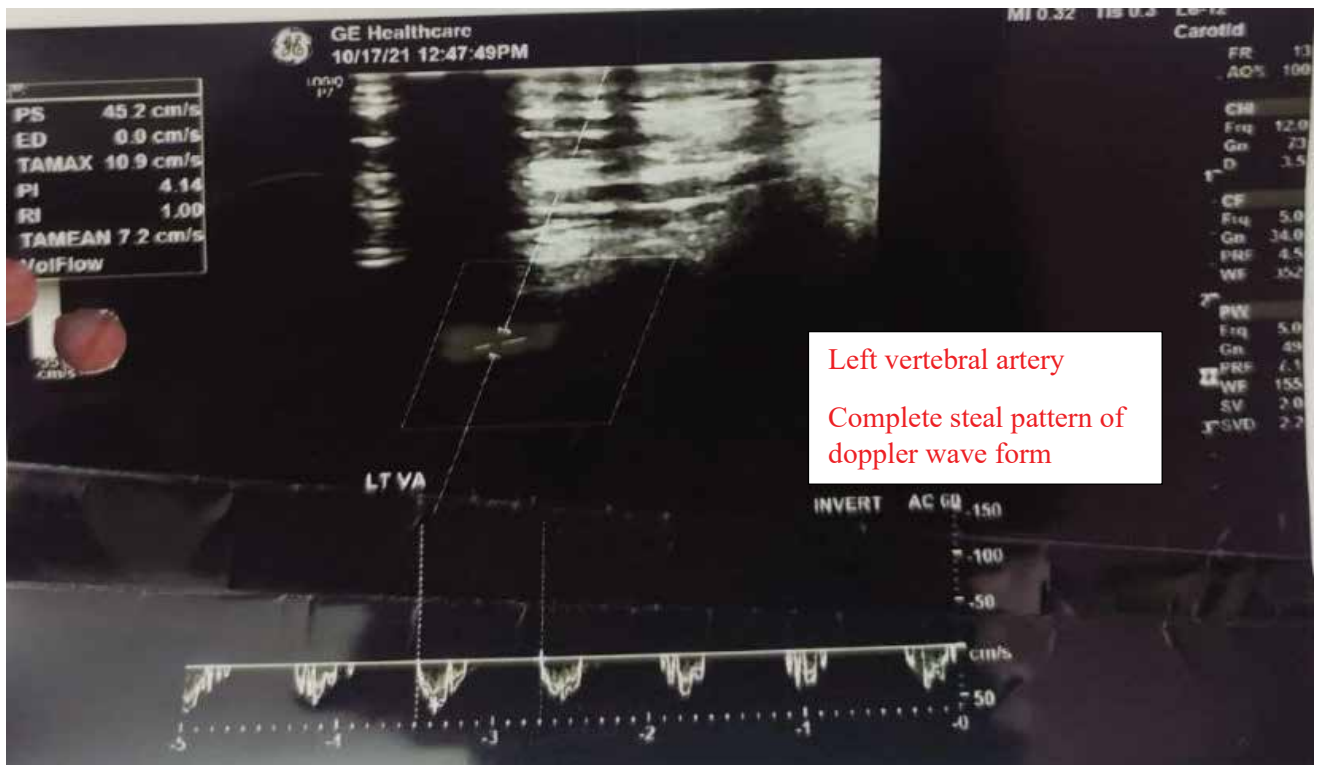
Duplex sonography: A Complete Steal Pattern of Doppler Waveform (below the baseline) is in the Left Vertebral Artery (VA)
